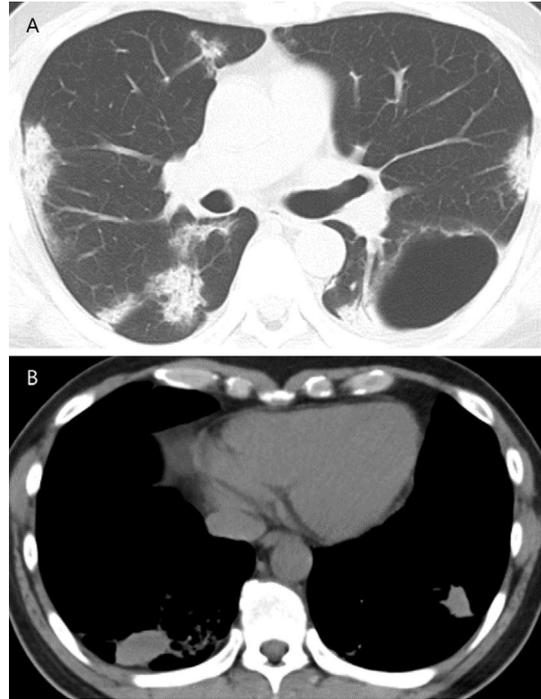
Chest CT scan on day 25 from the onset of COVID-19 (A, B).
